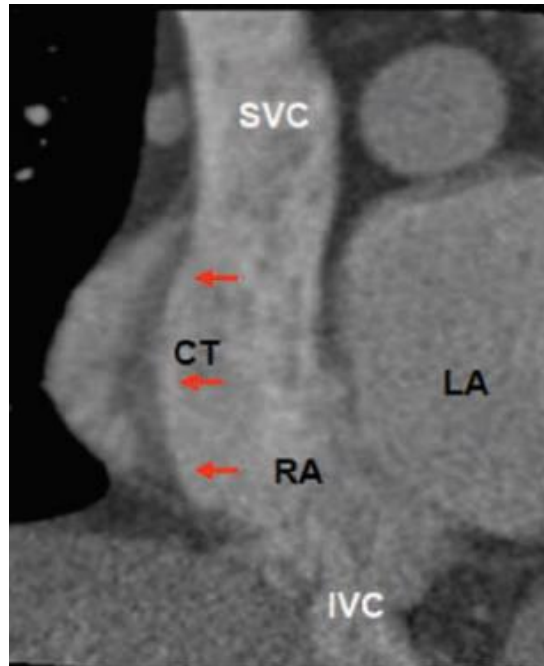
CT Short axis view showing the crista terminalis, the characteristic of RA (arrows) (*Quoted from Saremi and Sanchez-Quintana, 2011*).
